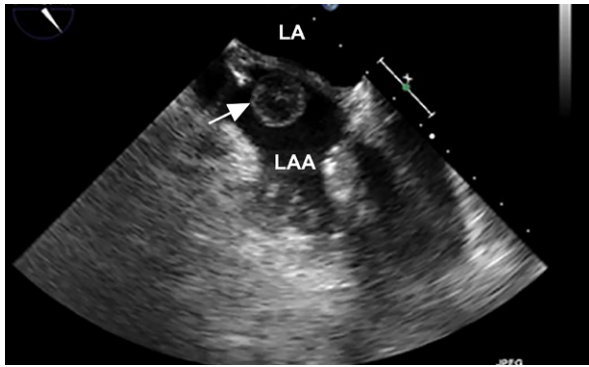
Patient 1. Transesophageal echocardiogram shows a 13.5 × 12.7-mm mass (arrow) between the left atrial appendage (LAA) and left upper pulmonary vein.
